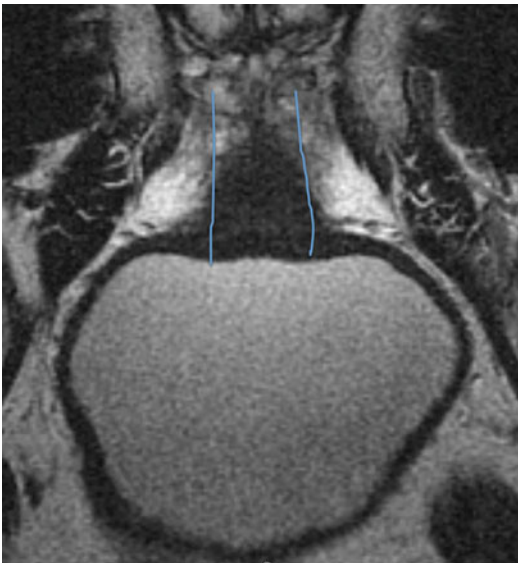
This is a corresponding MRI in coronal orientation and then flipped 180° to match the surgeon view. The *blue lines* show the division of the “rule of thirds” in dissection—see text. At this far anterior cut that corresponds to the beginning of the dissection, the tissues encountered are mostly the detrusor apron in the midline, and the run-off branches of the Santorini plexus laterally
